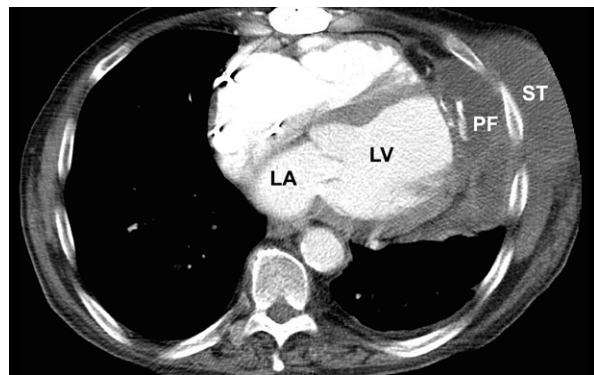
Computed tomographic angiogram of the chest shows the pericardial fluid collection (PF) extending through the chest wall into the subcutaneous tissue (ST) of the left anterior chest wall.
